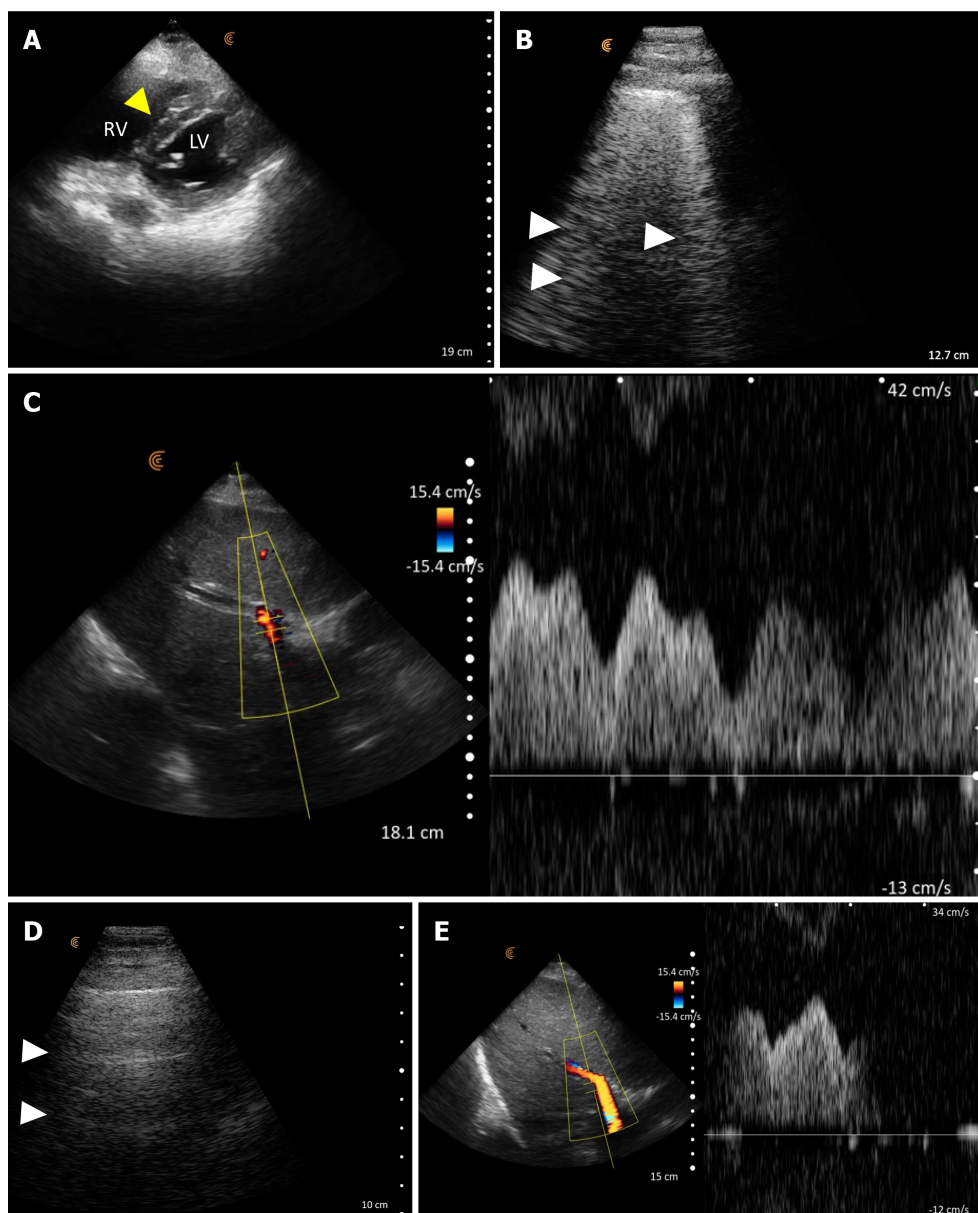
Point-of-care ultrasound images demonstrating stigmata of elevated cardiac filling pressures at the time of nephrology consult.
